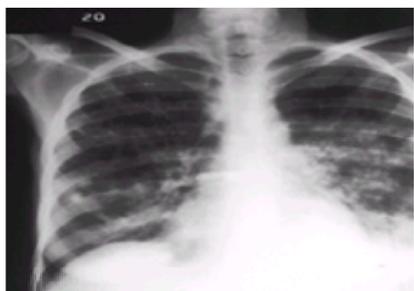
Chest radiograph of a patient with pulmonary parenchymal KS. The nodular densities suggest this diagnosis, especially in patients with cutaneous disease.
